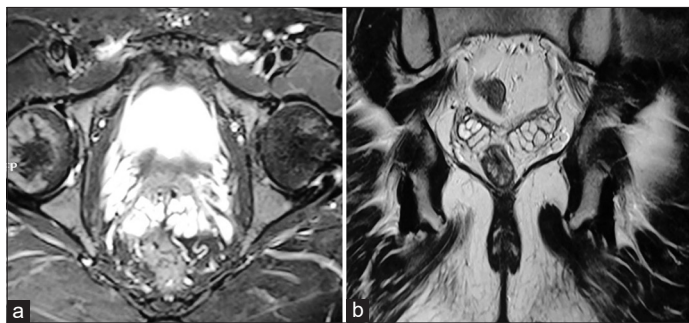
(a and b) Magnetic resonance imaging pelvis showing bulky bilateral seminal vesicles with hypointense calculus in terminal portion of the right seminal vesicle duct measuring 8.1 mm × 4.7 mm and another hypointense calculus in terminal portion of the left seminal vesicle duct measuring 6 mm × 3.6 mm
